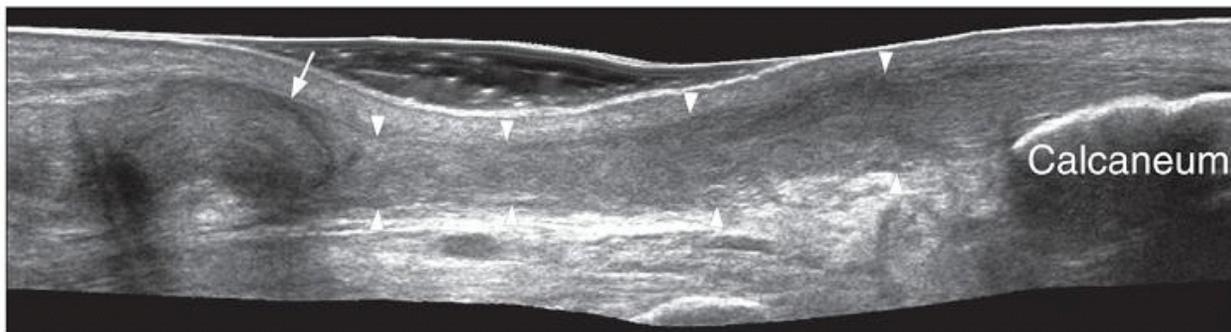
Longitudinal extended-field-of-view ultrasound of partial chronic Achilles tendon tear. The Achilles tendon (arrowheads) is elongated, although still continuous with a retracted tendon mass (arrow) close to the musculotendinous junction.
